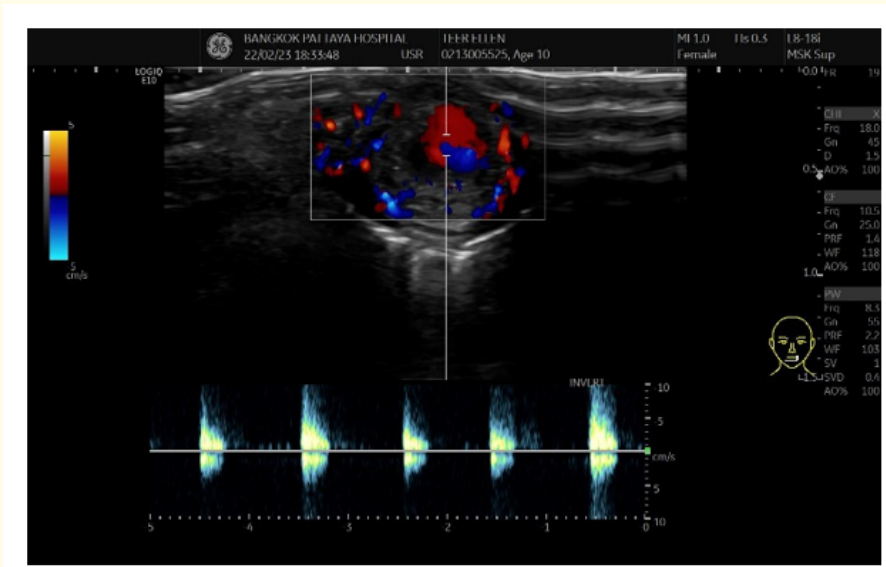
Color doppler ultrasound.
